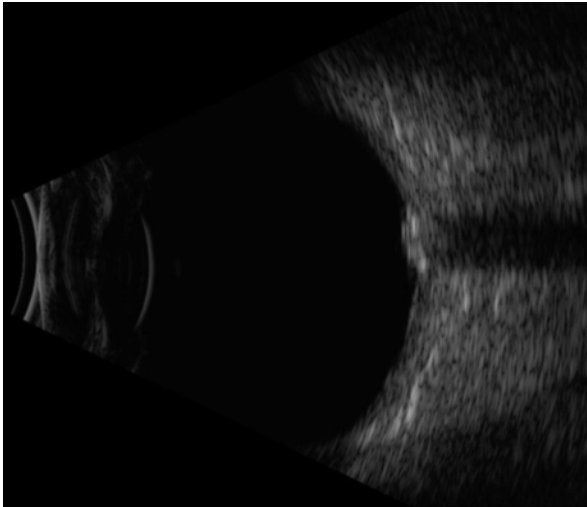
B-scan ultrasonography reveals a solid, dome-shaped, regularly structured lesion overlying the optic disc. Maximal elevation measures 1.6 mm. There is adjacent orbital shadowing secondary to calcification
